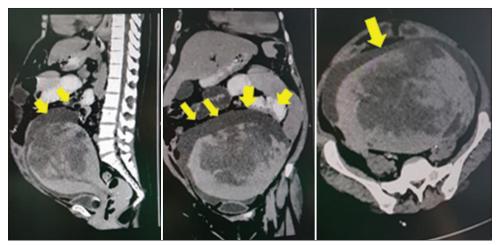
Computed tomography scan showing partial jejunal obstruction and tumor rupture (arrows)
